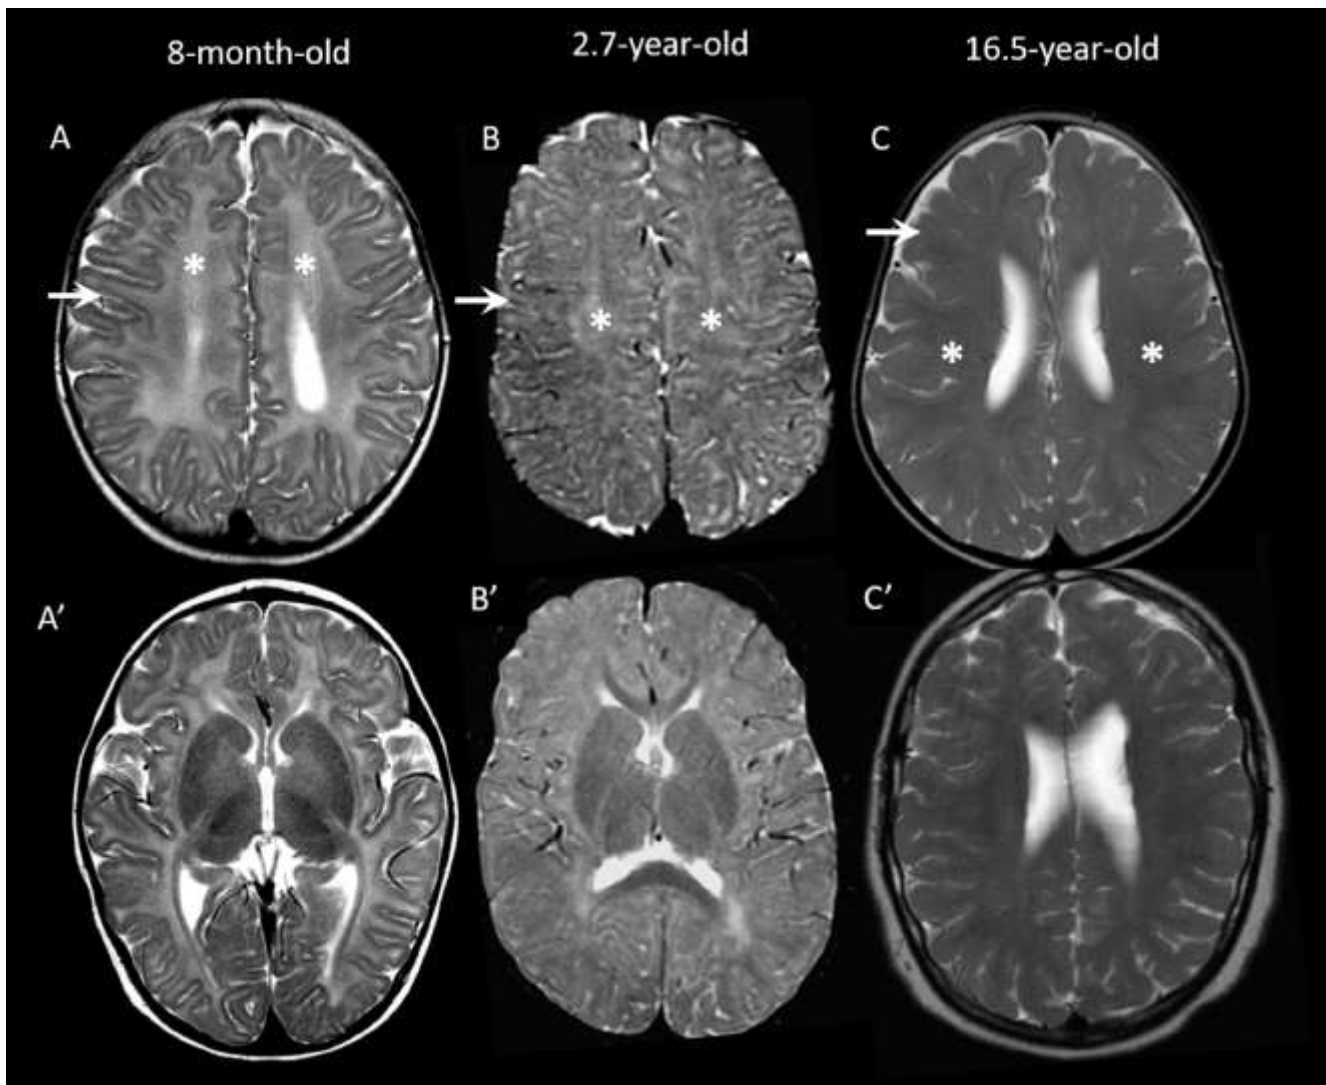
MRI patterns in three different cases. Images A, A' show a PMD-like pattern with diffuse T2-hyperintensity of white matter (asterisk A) and preserved GWMD (arrow A). Images B, B' show the "intermediate pattern" with mixed areas of preservation and loss of GWMD (arrow B) with dirty inhomogeneous white matter appearance (asterisk B). Images C, C' show the "washed-out pattern" with milder diffuse
